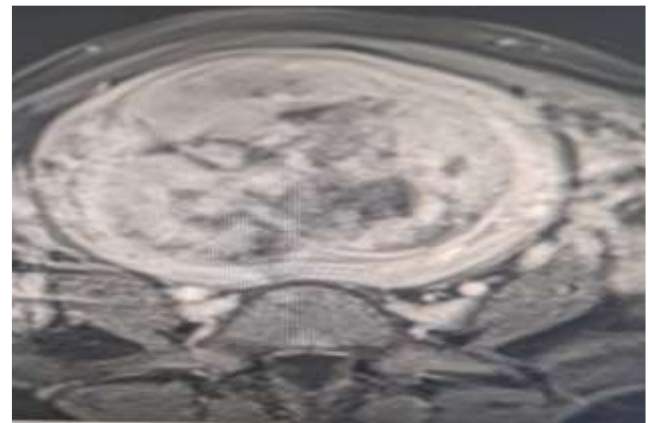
Early Heterogeneous Enhancement on Contrast-Enhancement MRI.
